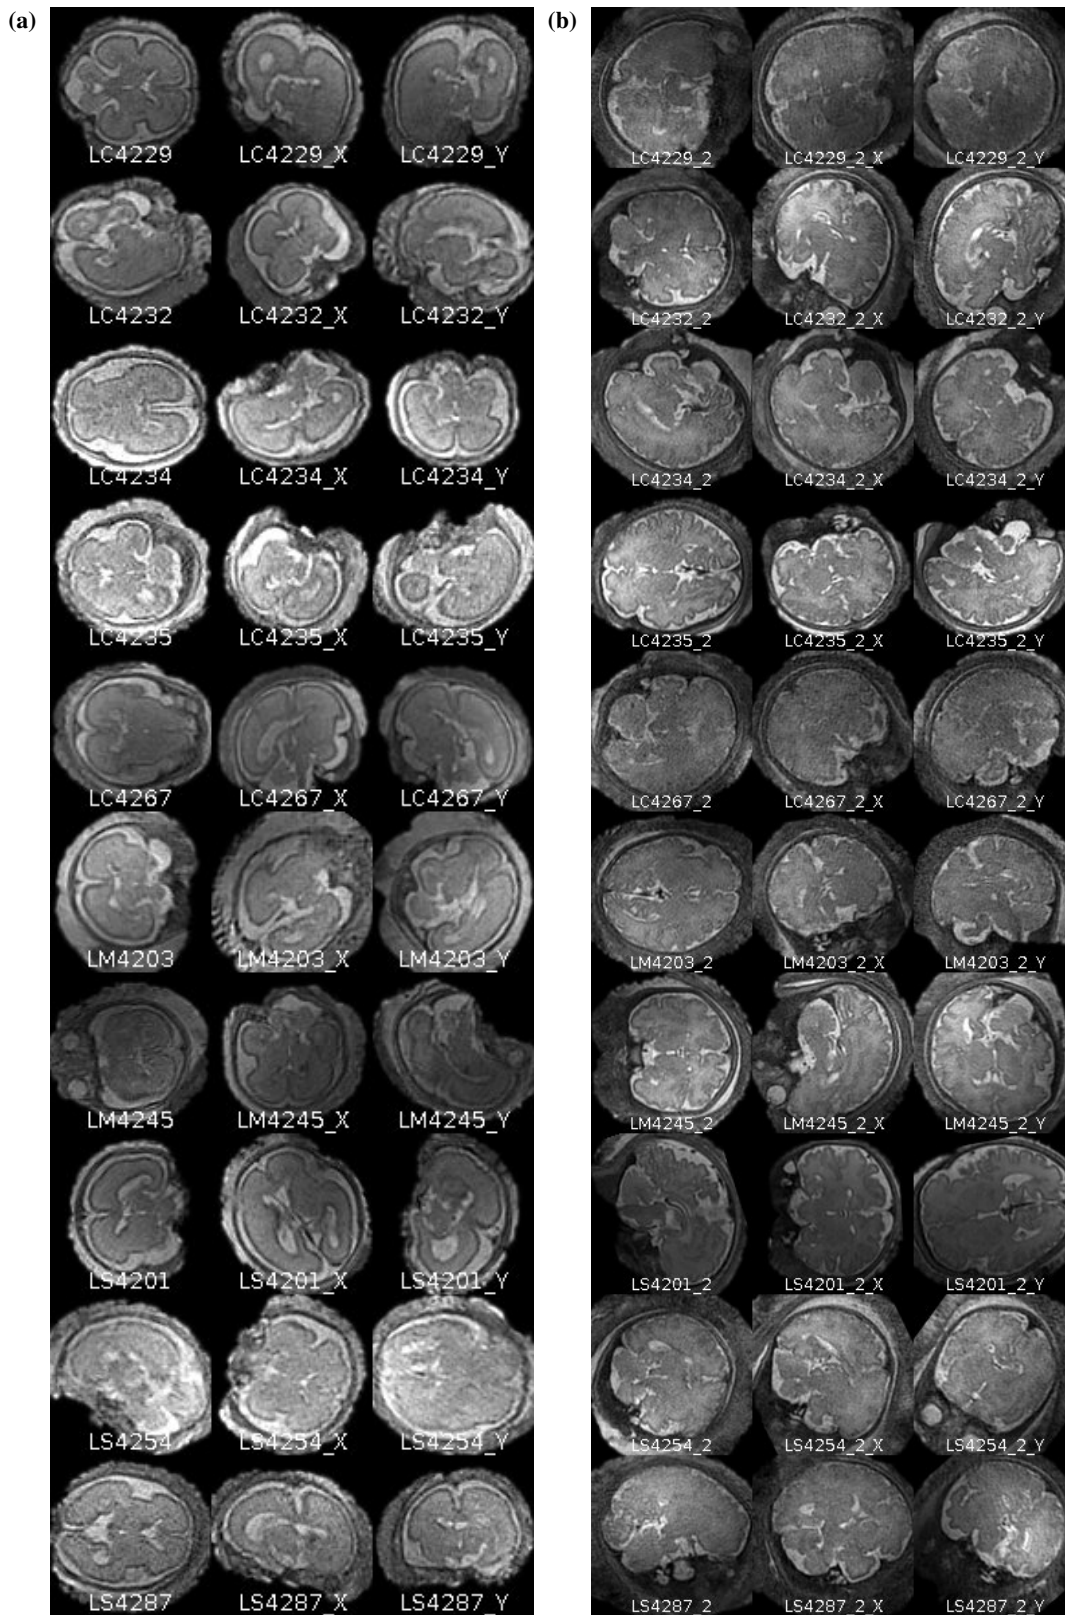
Ten fetal brains are displayed for triplets of orthogonal IR rotations in both the second and third trimesters of GA. Each row contains three central slices (i.e. pivotal planes) of orthogonal IR rotated MR images of one fetal brain in (a) the second or (b) the third trimester.
